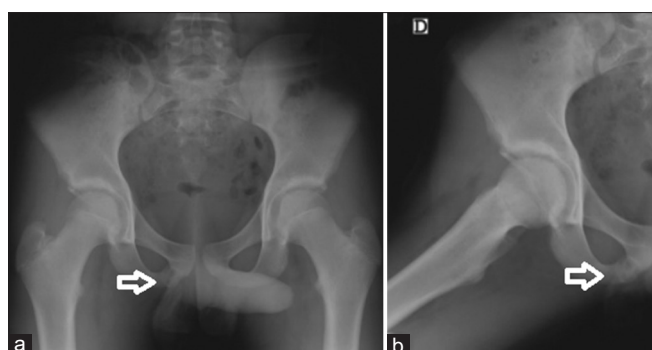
Anteroposterior and right lateral hip X-ray (a and b). On the right, a well-defined, rounded radiolucent area with sclerosis inside is identified, which represents ischiopubic synchondrosis
